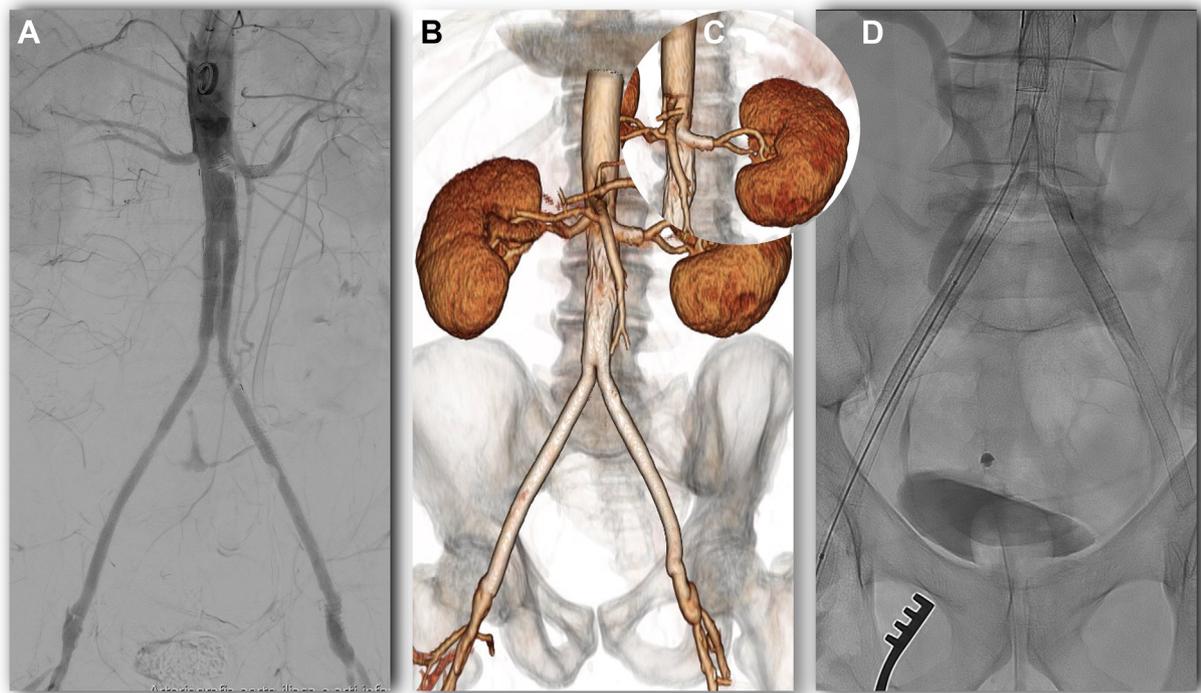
Total aortobifemoral (ABF) bypass recanalization images at final angiography (A) and postoperative computed tomography angiography (B). C, Detail of LRA stenting and bilateral iliac relining. D, LRA stenting and bilateral iliac relining.
